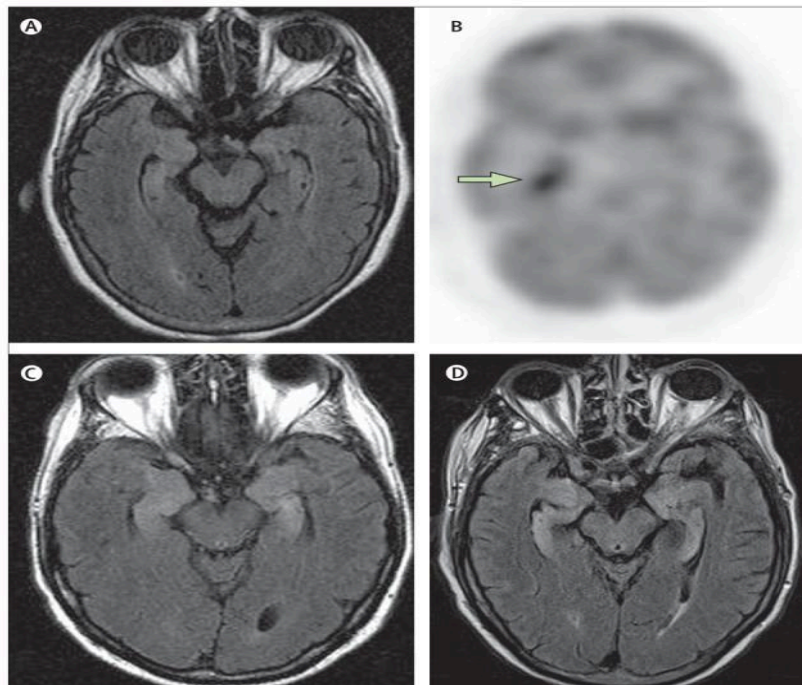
Neuroimaging of patients with encephalitis. A and B: patient with anti-Hu-associated sensory neuropathy. MRI of the brain (A) was normal. (B). A body fluorodeoxyglucose-PET scan that included the brain revealed an area of hypermetabolism in the right hippocampus C: typical increased FLAIR signal involving the hippocampi of a patient with paraneoplastic limbic encephalitis. D: medial temporal lobe FLAIR abnormalities and atrophy in a patient with a liver transplant who developed human herpes virus 6 (HHV6) encephalitis (mimicker of PNS-limbic encephalitis)
